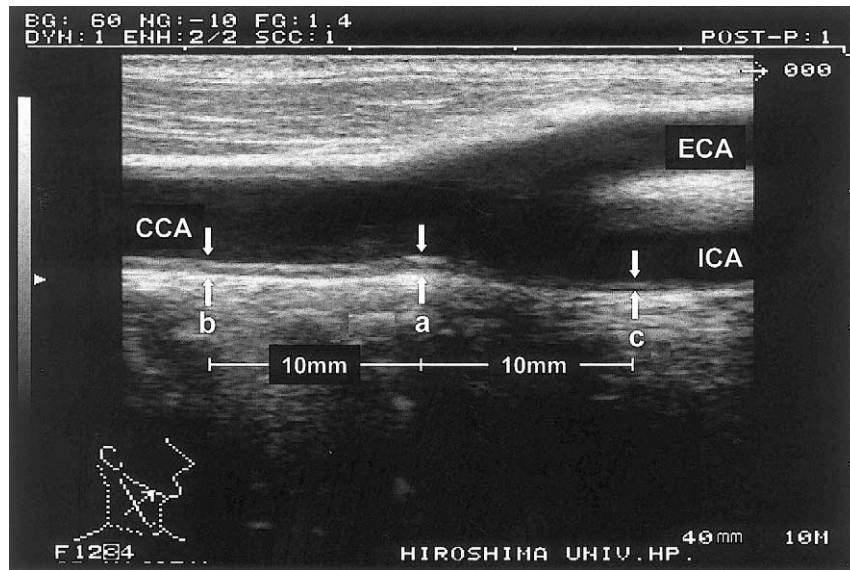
High-frequency B-mode ultrasound imaging of the common carotid artery (CCA), internal carotid artery (ICA) and external carotid artery (ECA). Three determinations of IMT were conducted at the site of greatest thickness (a) and at two other points, 1 cm downstream (b) and 1 cm upstream (c) from this site. These three determinations were averaged for evaluation.
